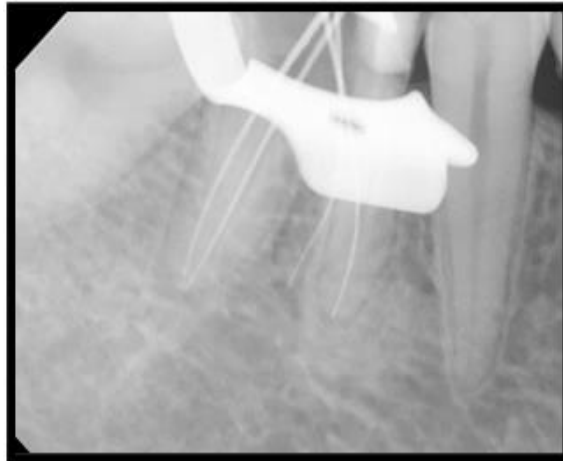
Working length radiograph of #46
